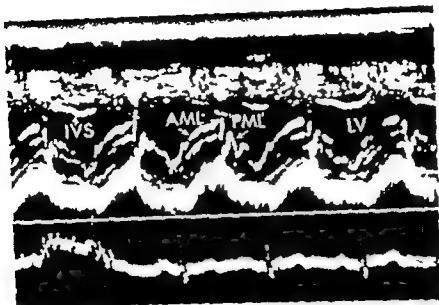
Echocardiogram in the mitral beam direction. A typical echocardiogram of a patient with the incomplete form of ECD with the beam passing from the mitral valve to the posterior wall of the left ventricle. The mitral valve shows systolic multiple echoes which have an abnormal round anterior motion and finish at the opening motion of the valve. In diastole only the so called posterior mitral leaflet (PML) is recorded without a trace of the anterior leaflet.
